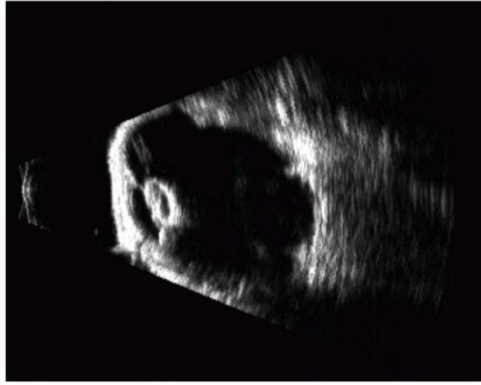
Artifacts posterior to a calcific cataract are seen, producing distortion and hypoechoic areas caused by deflection and absorption of the ultrasound beam.
